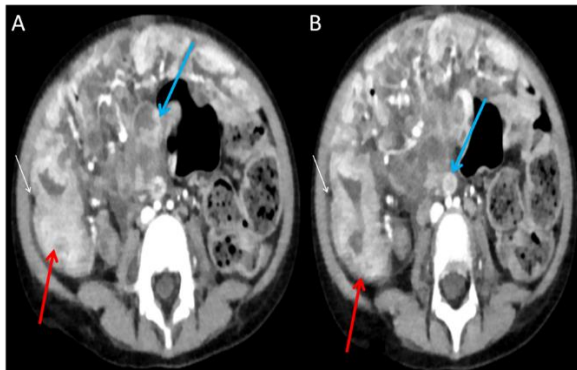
A and B axial enhanced computed tomography of the abdomen show multiple enlarged and low-density lymph nodes with peripheral enhancement (blue arrows), thickening of the ascending colon wall and cecum (red arrows), and ascites of the right paraglottic gutter (white arrows).
